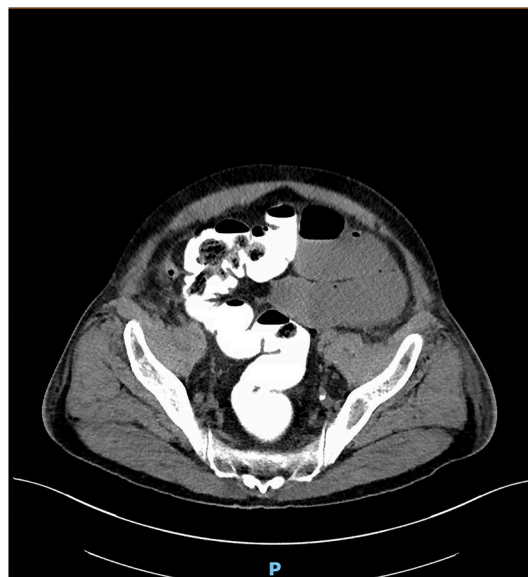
CT-Abdomen with rectal contrast.
